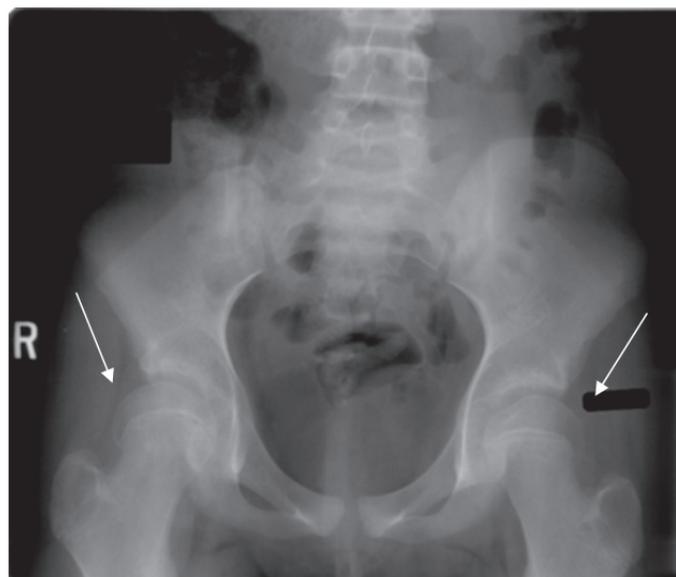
Bilateral valgus slipped capital femoral epiphysis located on both femurs. This condition occurred simultaneously on the left and right hips. The image depicts a plain X-ray of the pelvis prior to in situ pinning of either hip. (Case 3)
